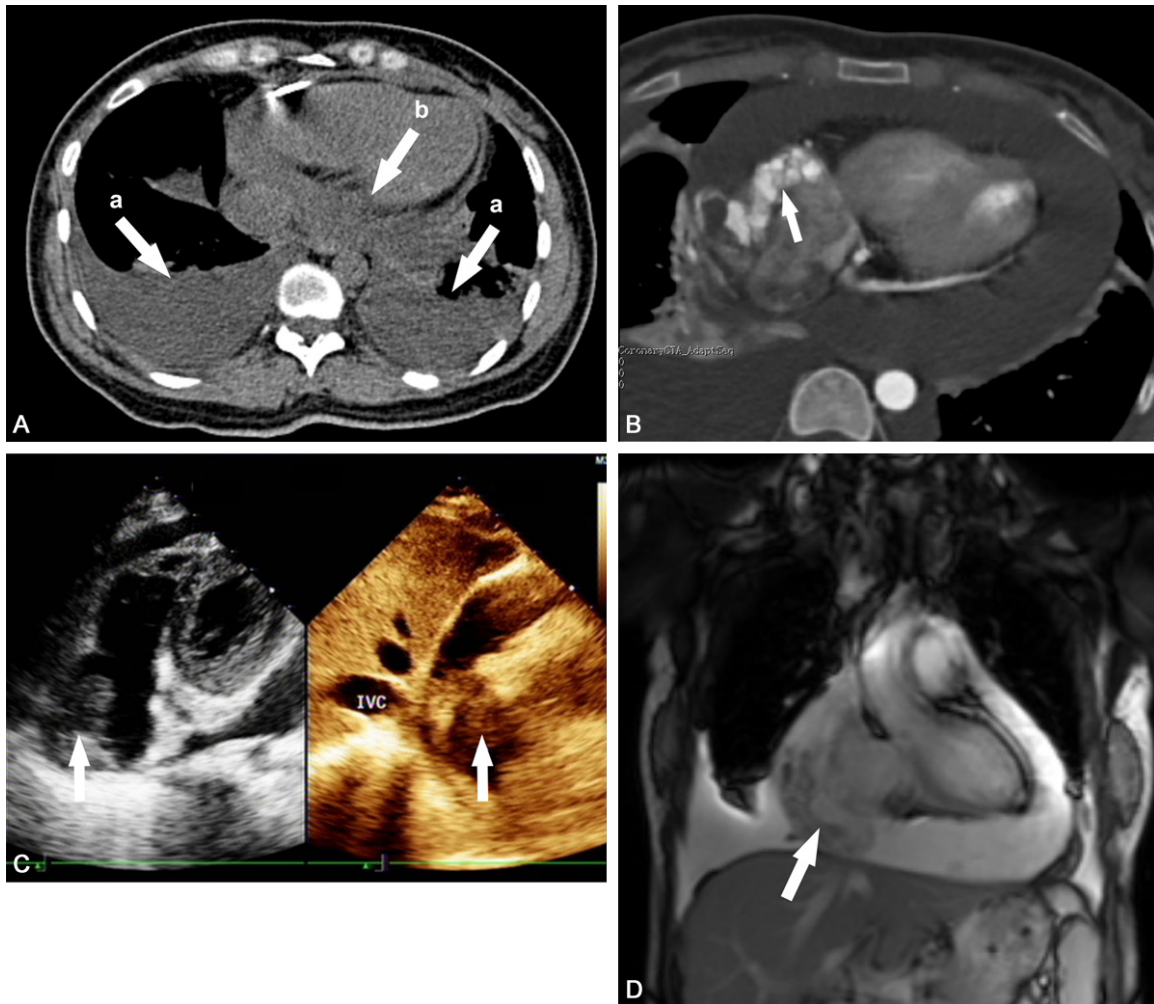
Radiological findings of the current patient by computed tomography (CT) and Color Doppler echocardiography before operation. (A) Pleural effusion in both sides (arrow a), as well as effusion in pericardial cavity effusion could be observed (arrow b) by CT. (B) After the effective drainage was performed, a solid irregular space-occupying lesion in the right atrium could be shown (arrow) by CT. Color Doppler echocardiography (C) and cardiac magnetic resonance (MRI) (D) both revealed a solid irregular space-occupying lesion in the right atrium with the size of 38 mm × 21 mm (arrow).
